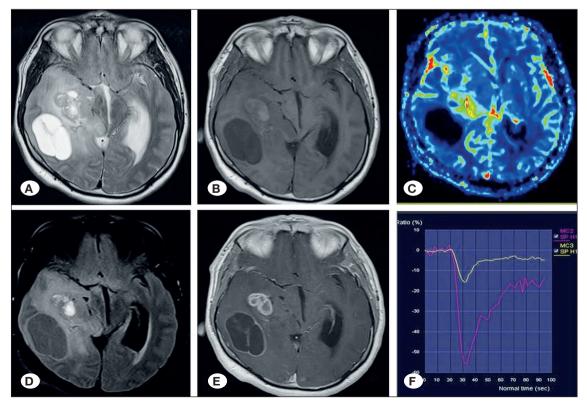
A 40-year-old male patient. Axial T2-weighted (A), FLAIR (B), T1-weighted (C), and contrast-enhanced T1-weighted (D) images reveal a tumor with cystic and solid components in the right parietal and temporal lobes. The CBV map (E) and time-to-signal intensity curve (F) are shown. The rCBVmax is 5.05 and the PSR¹ is 0.49. The pathological diagnosis was IDH-wild-type glioblastoma.
